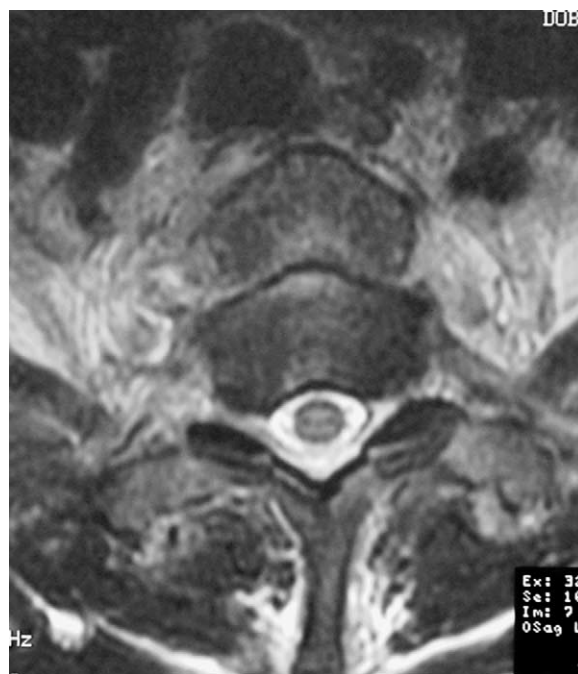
Axial MRI showing the luxation and the almost total overlap of the two vertebrae.
